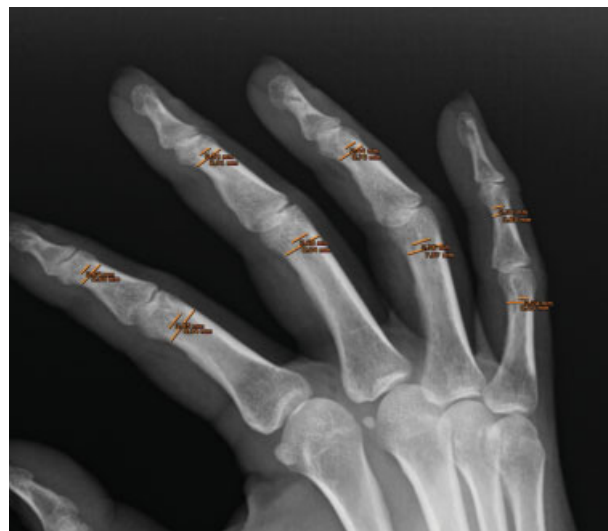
Measurement of the proximal and medial phalanges of the large fingers in an oblique radiograph using IRE Image Channel software (IRE Rayos X S.A., Madrid, Spain).
